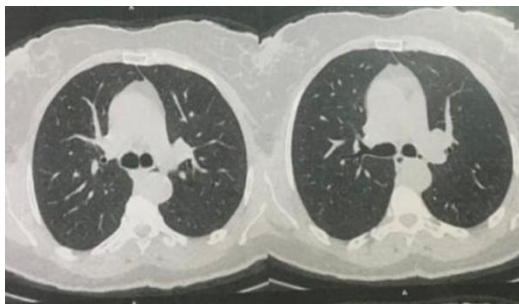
Normal Thoracic CT scan
